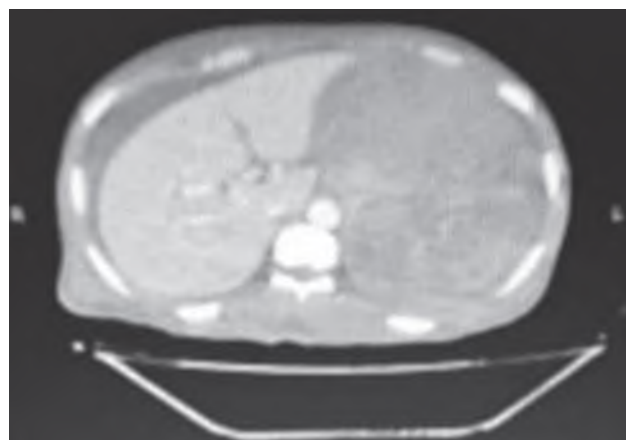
Axial view of abdominal CT showing massive splenic hematoma.
